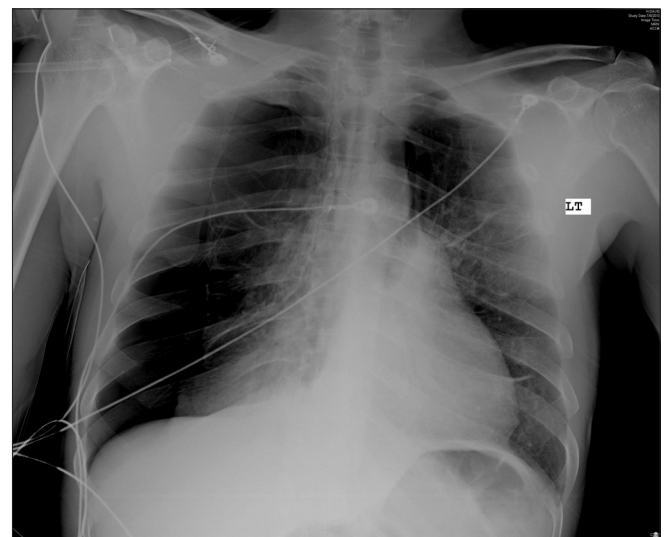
Chest radiograph showing right-sided pneumothorax on presentation
